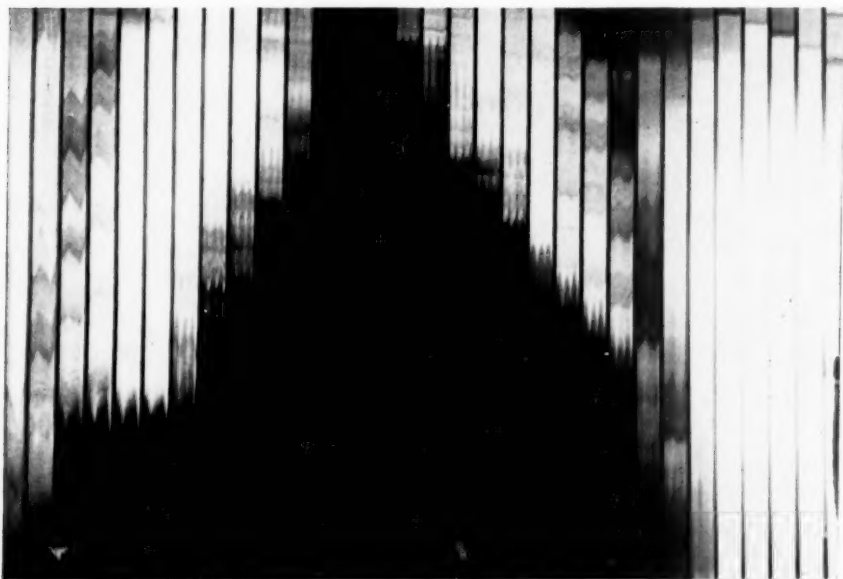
Roentgenkymogram which shows the pulsations of the diaphragm transmitted from the underlying liver. The diaphragmatic pulsations are synchronous with those of the aorta and superior vena cava.
